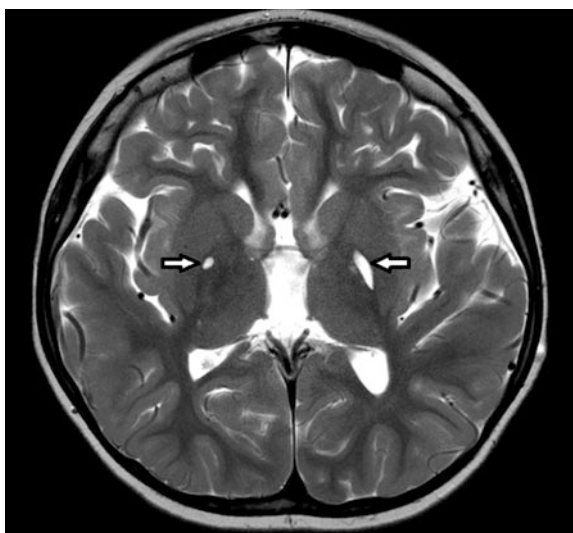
MR brain at 4-month follow-up. Axial T2-weighted sequence demonstrates bilateral hyperintensities in the globus pallidi (arrows)
